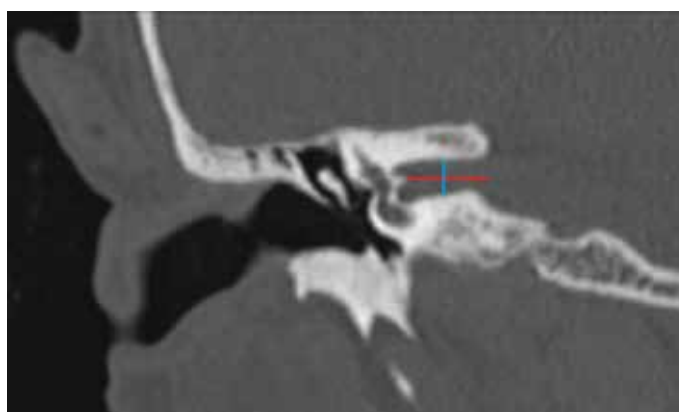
IAC length (red line) and width (blue line) measured from coronal reformat CT images
